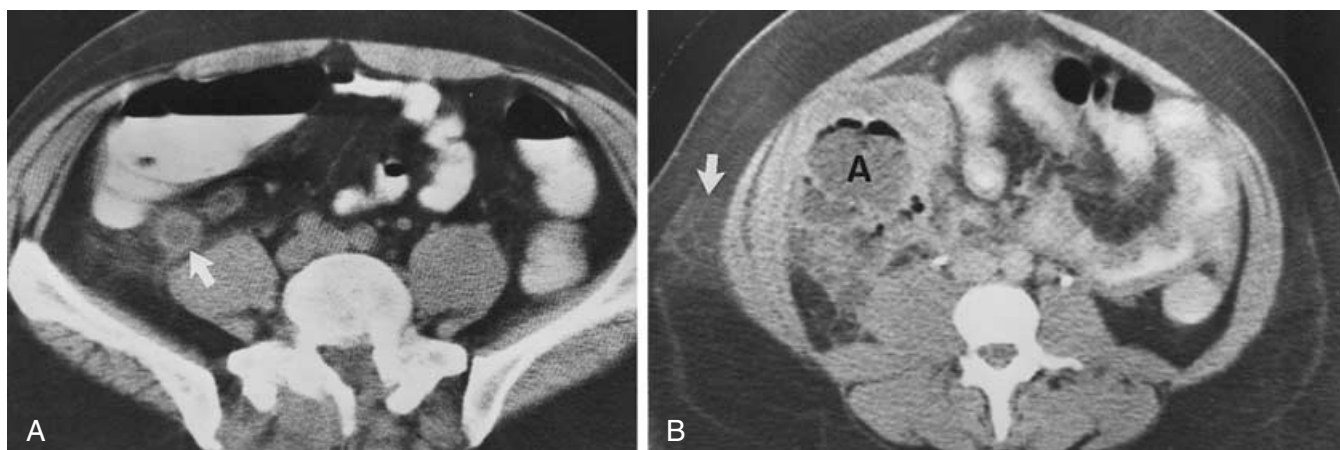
Appendicitis. A, CT scan of uncomplicated appendicitis. A thick-walled, distended, retrocecal appendix (*arrow*) is seen with inflammatory change in the surrounding fat. B, CT scan of complicated appendicitis. A retrocecal appendiceal abscess (A) with an associated phlegmon posteriorly was found in a 3-week-postpartum, obese woman. Inflammatory change extends through the flank musculature into the subcutaneous fat (*arrow*).
